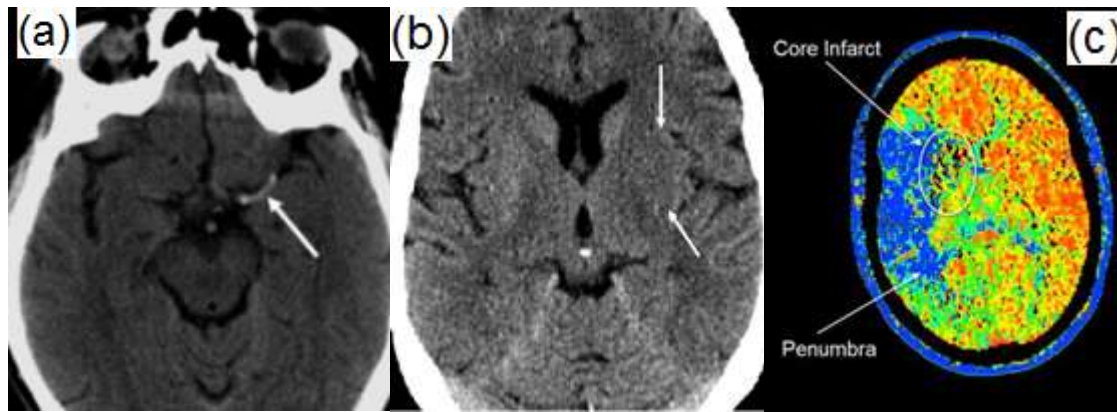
(a) Axial NCCT Brain image showing hyperdense left MCA (proximal segment), (b) Hypoattenuation and obscuration of the left lentiform nucleus in acute ischemia in the lenticulostriate distribution (c) CT perfusion study showing infarct core and salvageable penumbra.
